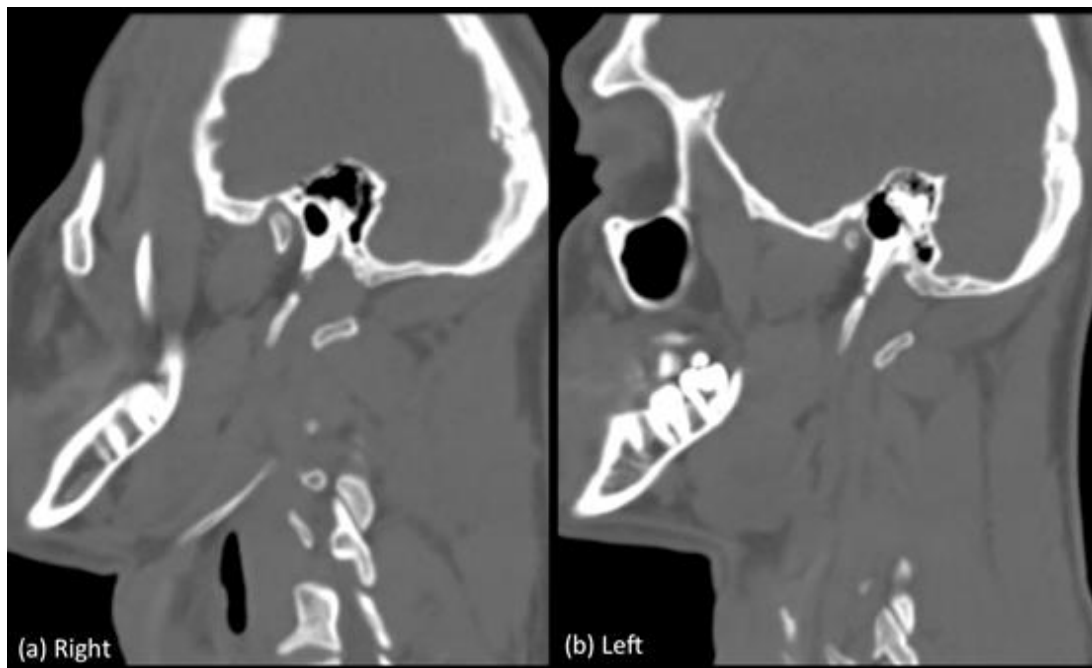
CT sagittal oblique multiplanar reconstruction of the neck
